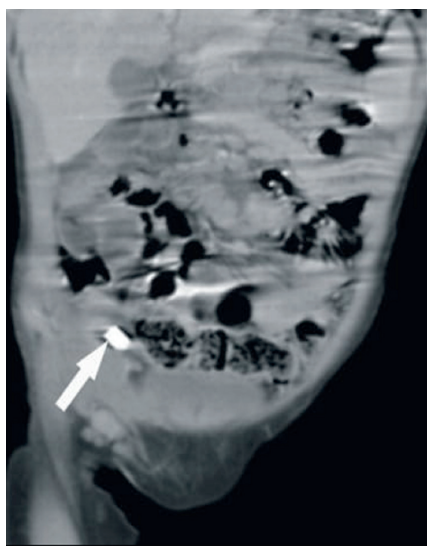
Computed tomography image (coronal section). Foreign body (arrow) extending into the right inguinal region
